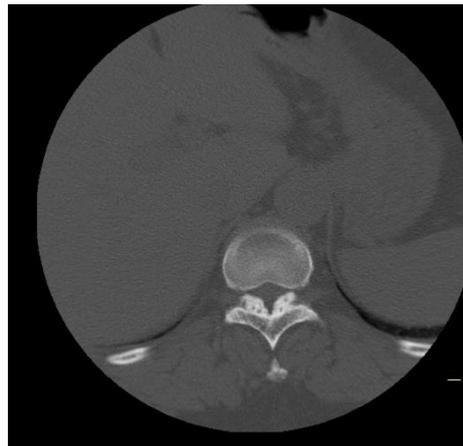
Axial CT scan at the level of the T11 with V shaped OLF.
